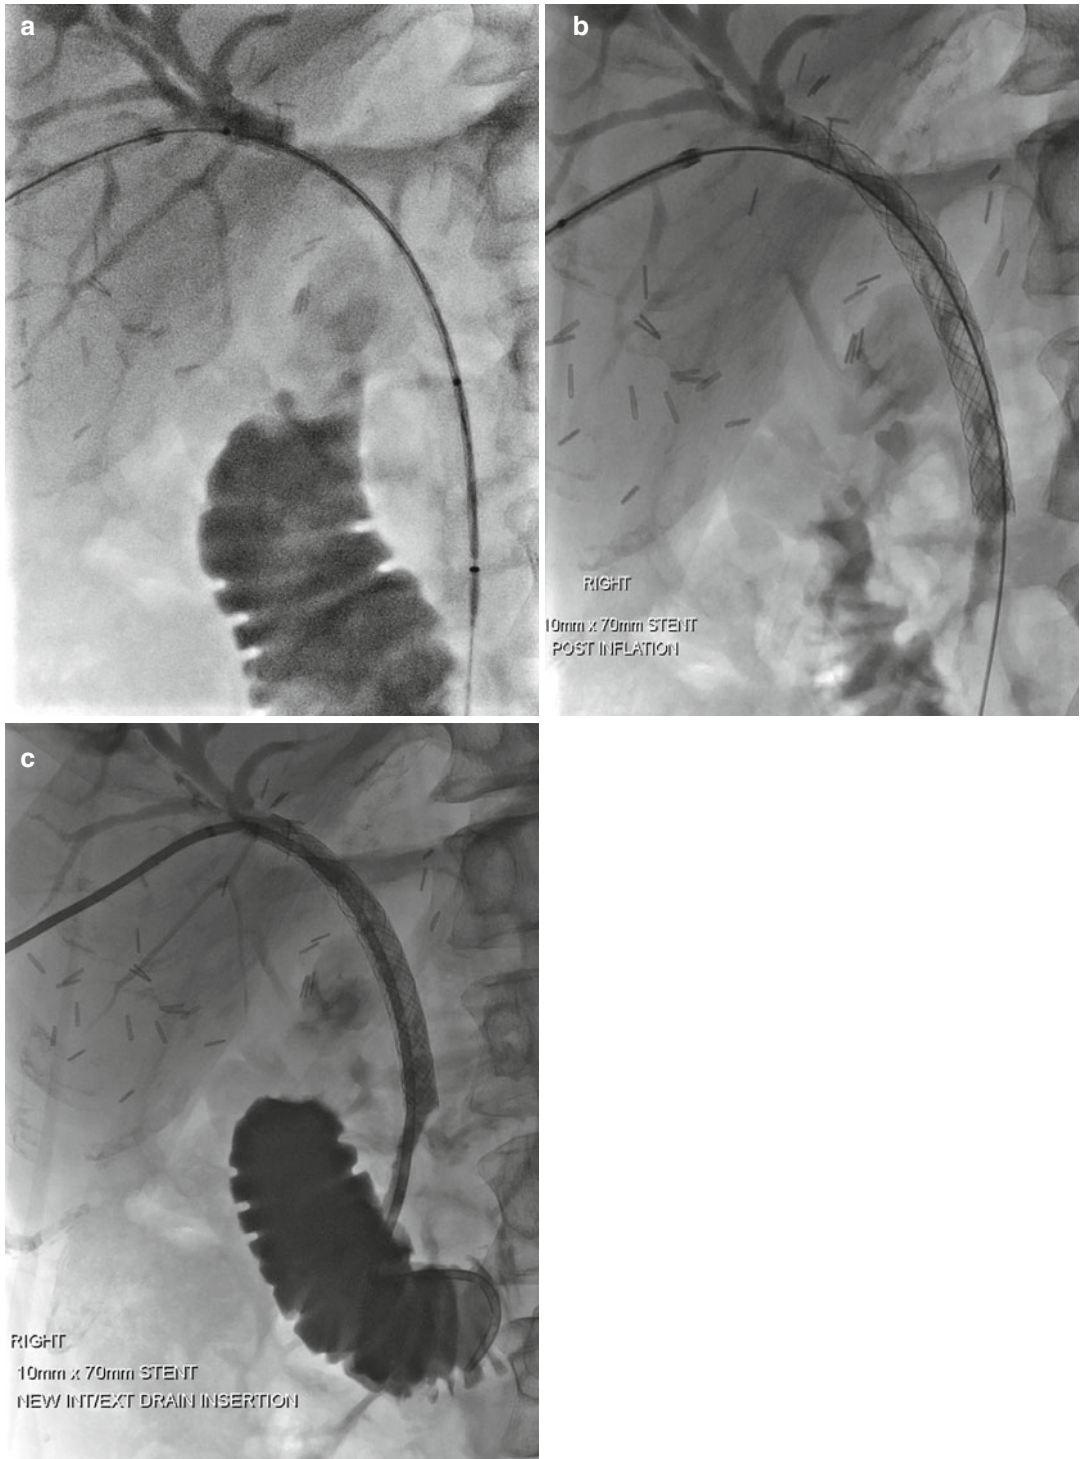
(a–c) Biliary stent. (a) Procedural x-ray with wire and catheter across hilar and CBD stricture following percutaneous cholangiogram. (b) Post deployment and balloon
